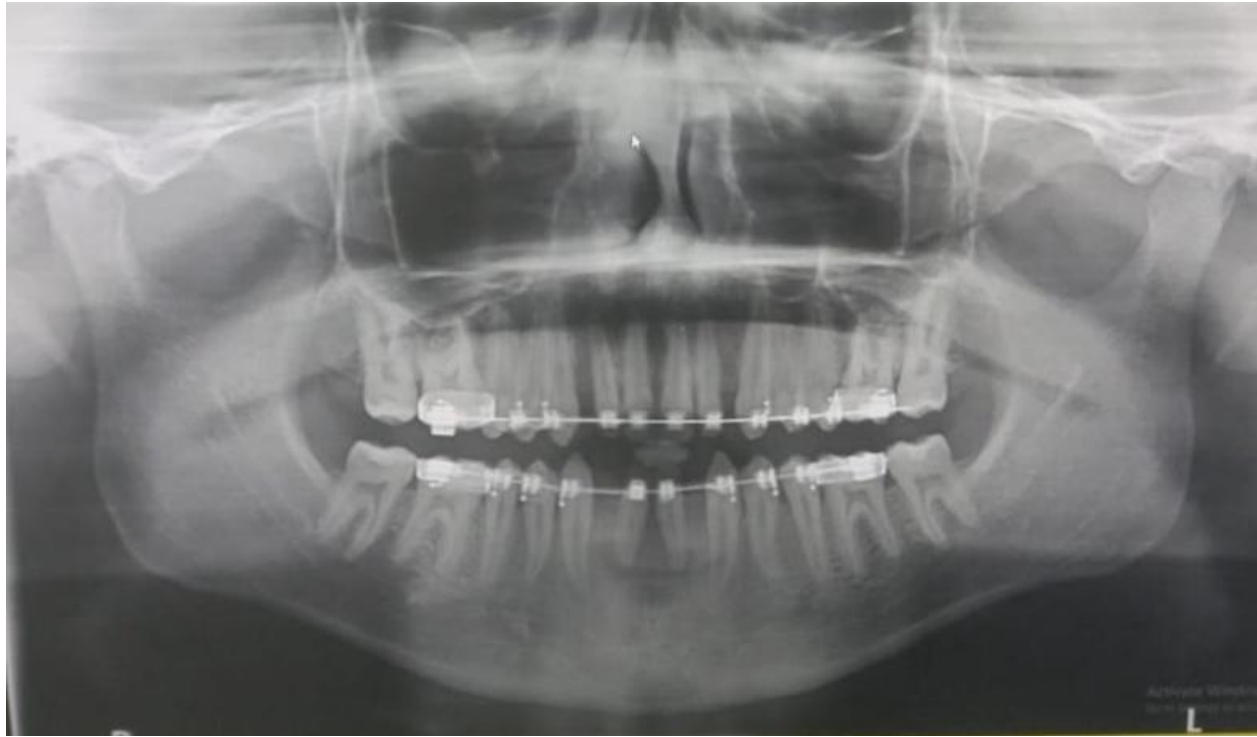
The panoramic radiograph.
